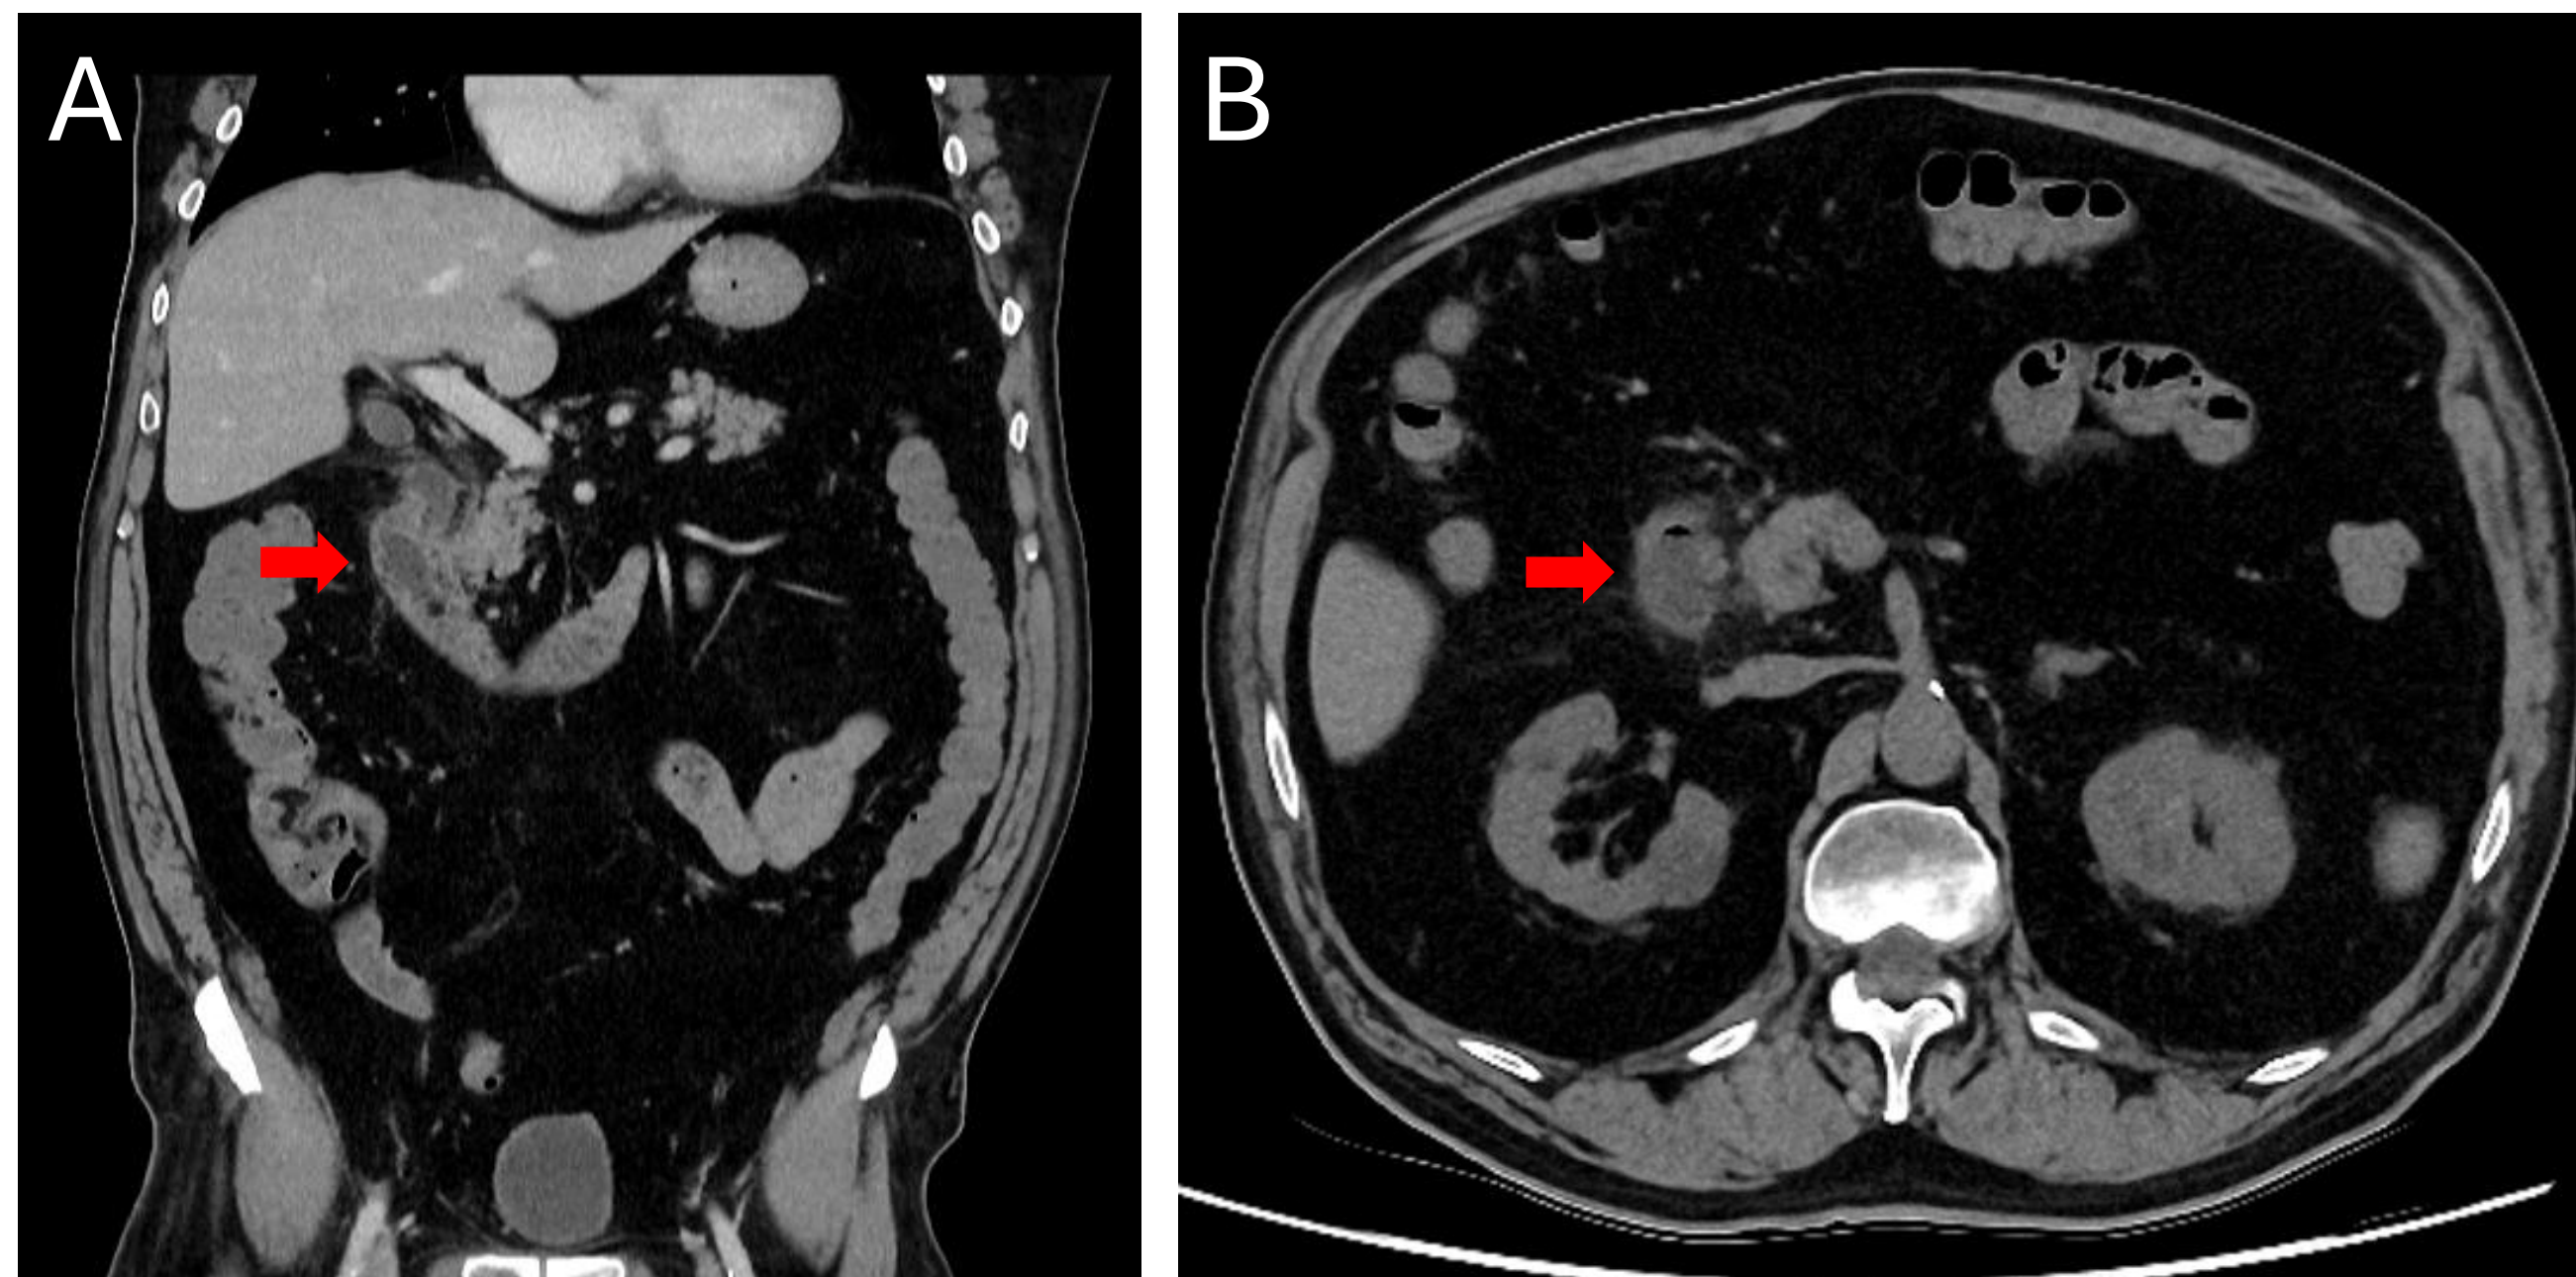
CT Imaging on Discharge showing Duodenal Improvement.
